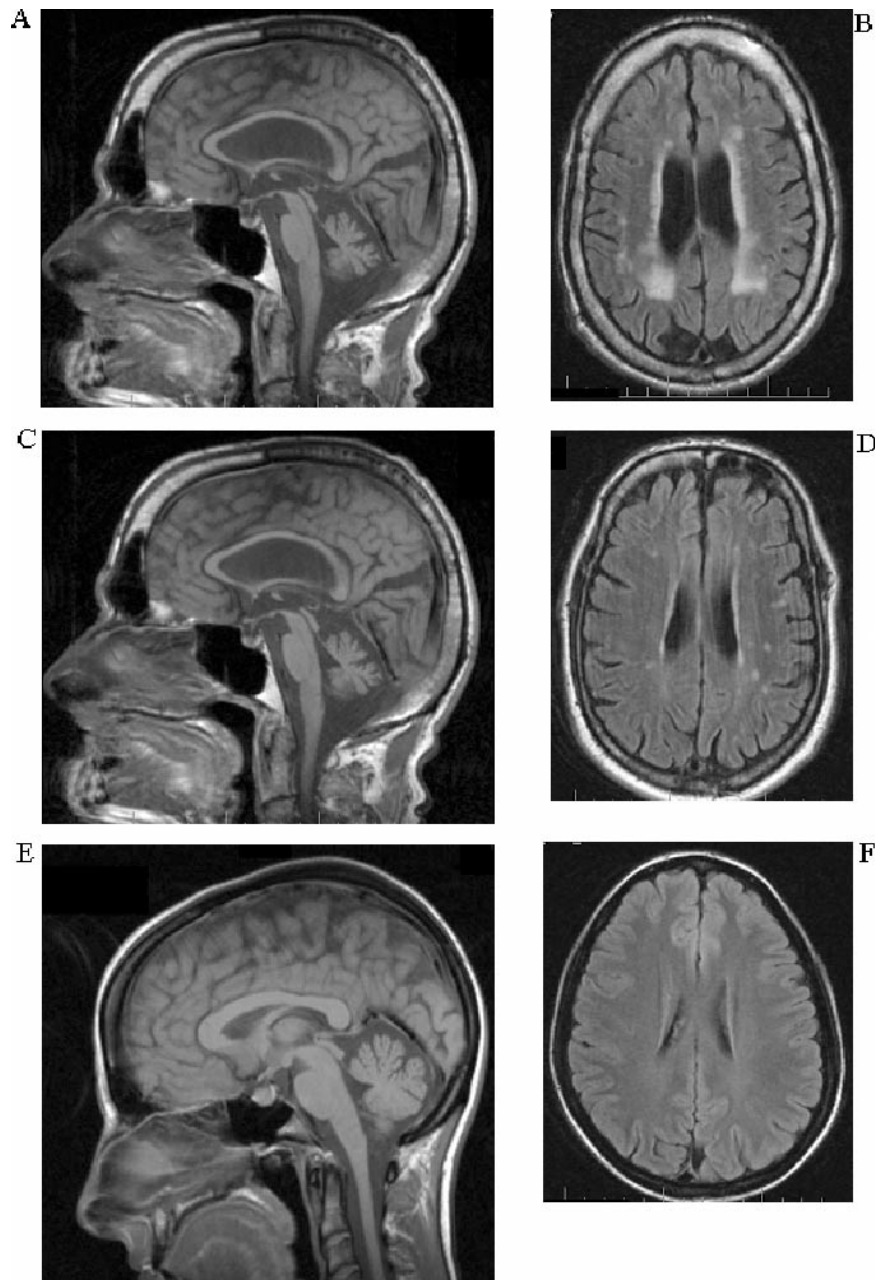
Sagittal and coronal T₂-weighted MRI sequences demonstrating the variable cerebellar atrophy and white matter changes in three ARSAL cases. (A and B) Case 4 is the 52-year-old brother of Case 5 who has a more severe form of ARSAL. (C and D) Case 5 is the 46-year-old younger brother of Case 4 who has a less severe form of ARSAL. The degree of cortical and cerebellar atrophy and of white matter changes seem to correlate in this family (B) with the severity of the disease. (E and F) 30-year-old case with a mild-to-moderate ARSAL phenotype that is clearly less severe than that of Cases 4 and 5 (A, B, C and D). At age 30 she only has cerebellar atrophy and no white matter changes (Family E, Case 10).
